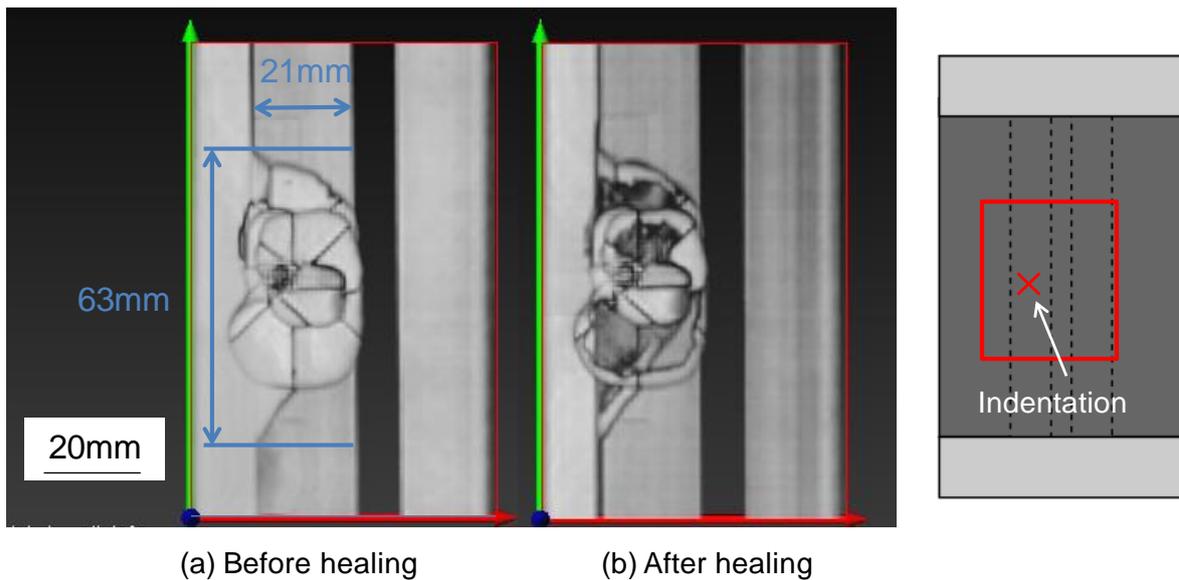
Ultrasonic observation of internal damage.
